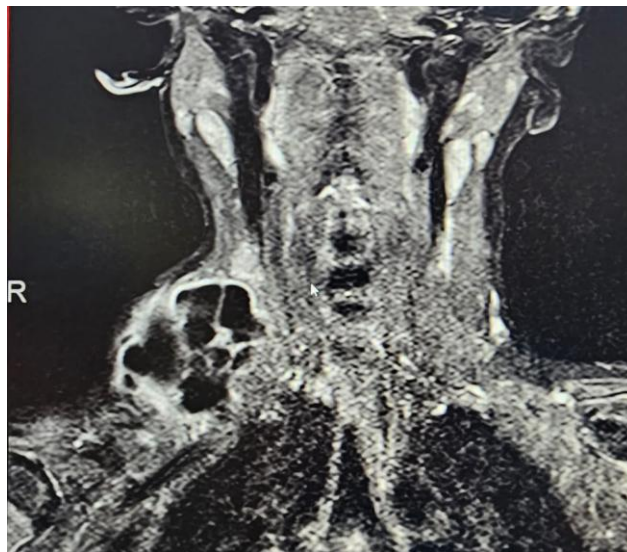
MRI showing giant cystic lymphangioma in right lower neck
